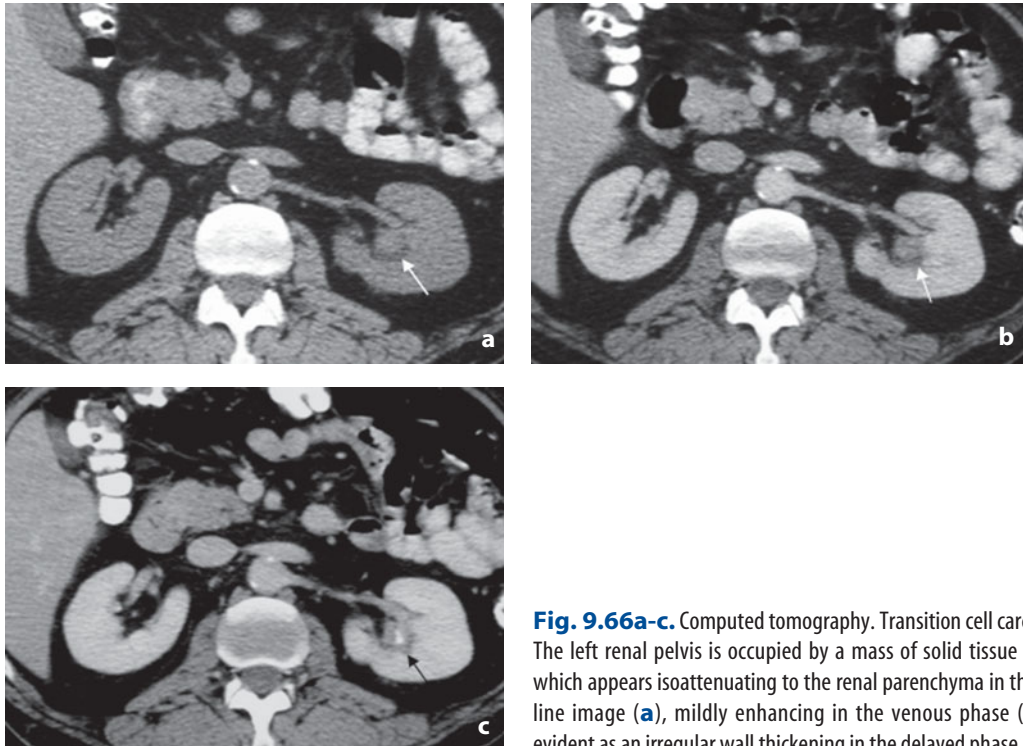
Computed tomography. Transition cell carcinoma. The left renal pelvis is occupied by a mass of solid tissue (*arrow*) which appears isoattenuating to the renal parenchyma in the baseline image (a), mildly enhancing in the venous phase (b) and evident as an irregular wall thickening in the delayed phase (c)
